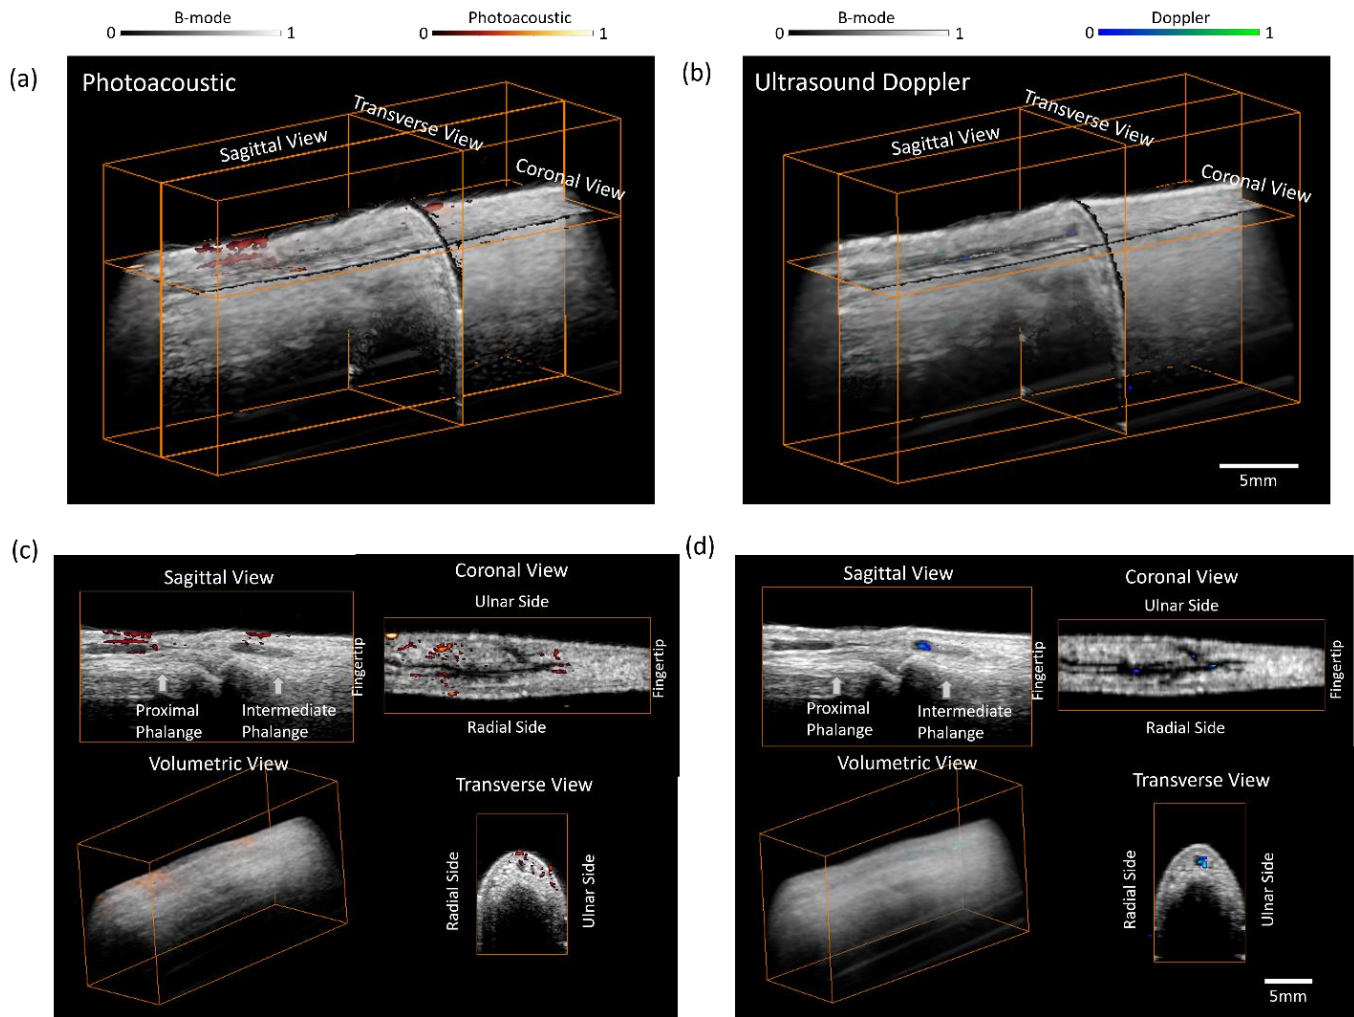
3D volumetric rendering of (a) the B-mode and PA image and (b) the B-mode and Doppler US image of a healthy control's right PIP3 joint. The 2D images along different views are shown in (c) and (d), where the plane for each view is marked in (a) and (b),.
